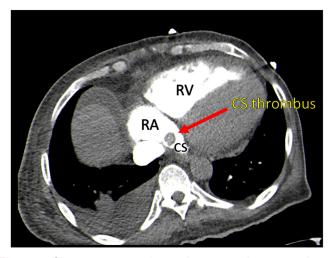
Chest contrast-enhanced computed tomography at the level of the CS demonstrates a round-shaped hypodense-filling defect (*arrow*) in the RA and CS junction measuring 14 mm  $\times$  18 mm representing a CS thrombus. Also seen is a right-sided pleural effusion.
